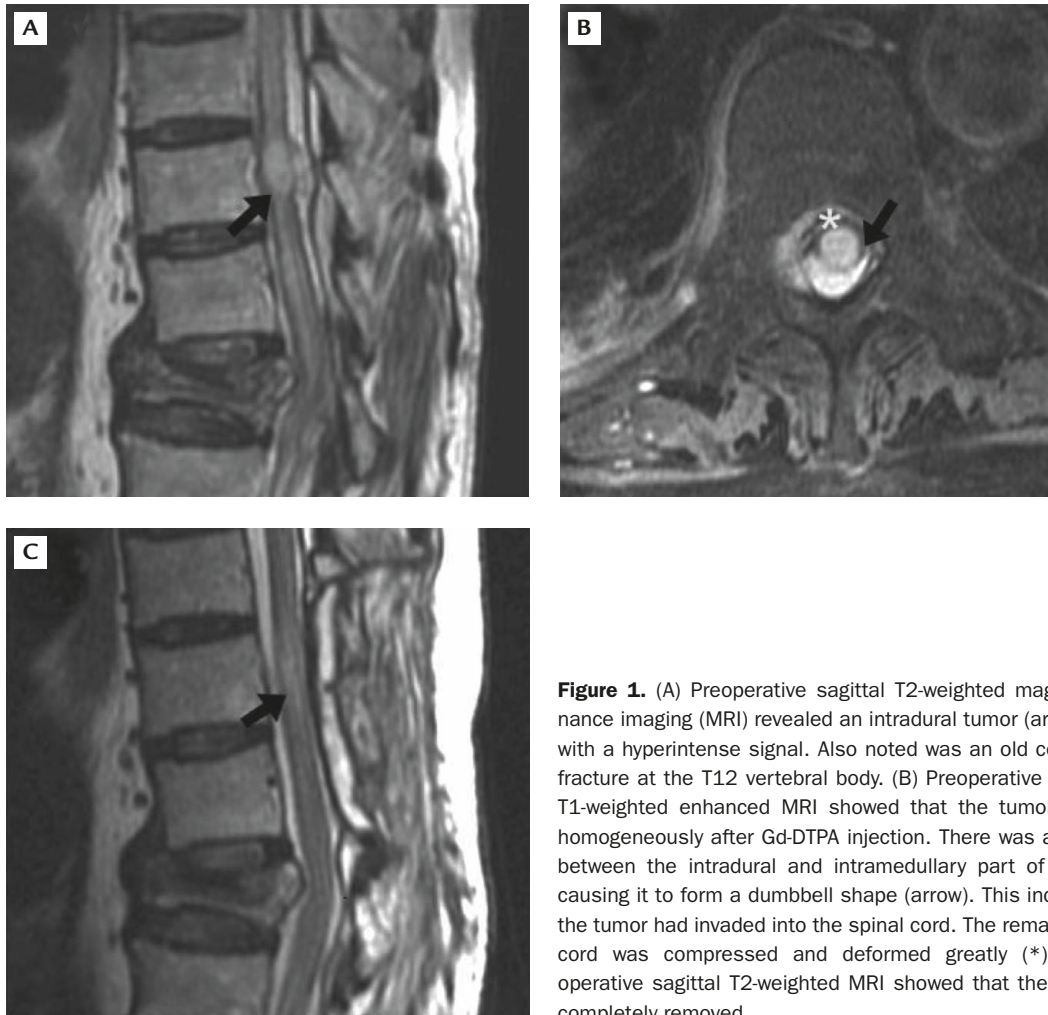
(A) Preoperative sagittal T2-weighted magnetic resonance imaging (MRI) revealed an intradural tumor (arrow) at T10 with a hyperintense signal. Also noted was an old compression fracture at the T12 vertebral body. (B) Preoperative axial cut of T1-weighted enhanced MRI showed that the tumor enhanced homogeneously after Gd-DTPA injection. There was a thin plane between the intradural and intramedullary part of the tumor, causing it to form a dumbbell shape (arrow). This indicated that the tumor had invaded into the spinal cord. The remaining spinal cord was compressed and deformed greatly (*). (C) Post-operative sagittal T2-weighted MRI showed that the tumor was completely removed.
